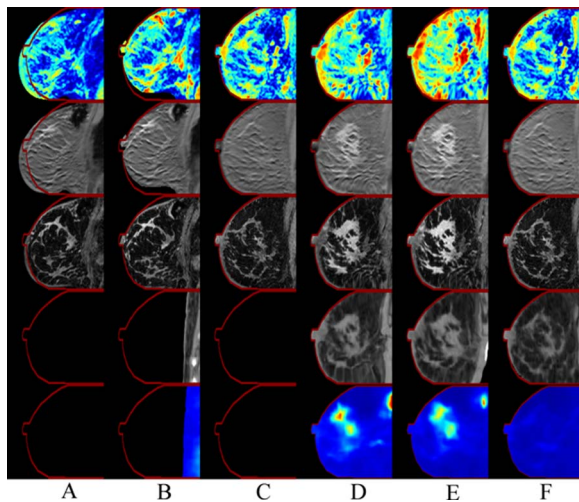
Columns A, B, and C correspond to the images before registration acquired at baseline before initiation of NAT (t_1), after one cycle of NAT (t_2), and at the conclusion of NAT (t_3). Columns D, E, and F correspond to the images after both intra- and interscanning session registrations. The rows correspond to the ADC, postcontrast DCE-MRI, THRIVE-MRI, CT, and the SUV of the FDG-PET, respectively. The contour of the THRIVE image at t_3 was copied to the other images in order to facilitate visual comparison of the registration results. The patient was a nonresponder (i.e., a non-pCR).
